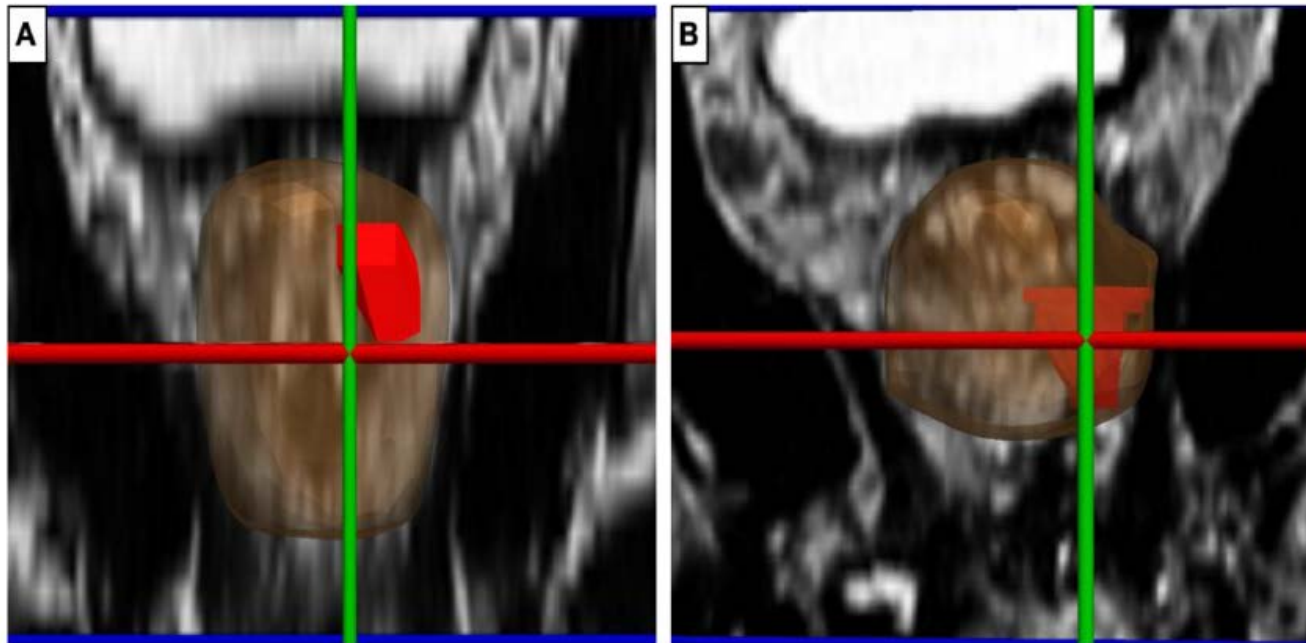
Pre- and post-treatment multiparametric MRI reformatted images of the prostate and region of interest. The figure shows reformatted (A) pretreatment (gland size 43 mL) and (B) post-treatment (gland size 28 mL) T2 multiparametric MRI coronal images for subject 4. The red is the target (region of interest) and the brown is the prostate. The cross hairs in the 2 images show the center of the image as acquired. In reference to the prostate, the bladder lies superiorly and the obturator muscles (which are black) laterally. (Color version available online.)
